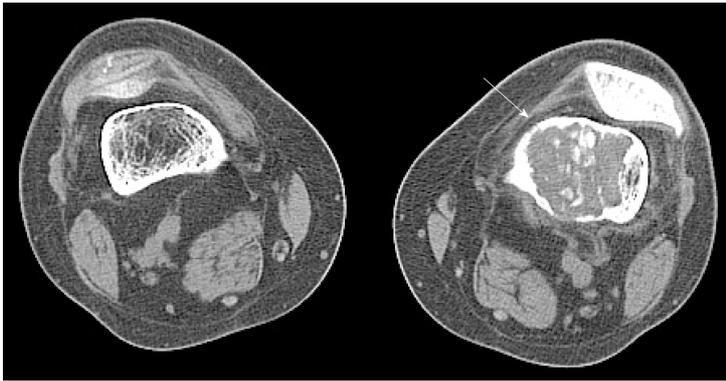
Computed tomography scans of knee joints. Mixed density shadows are shown in the intramedullary cavity of the left femur (arrow). Computed tomography values are 45-70 HU.
